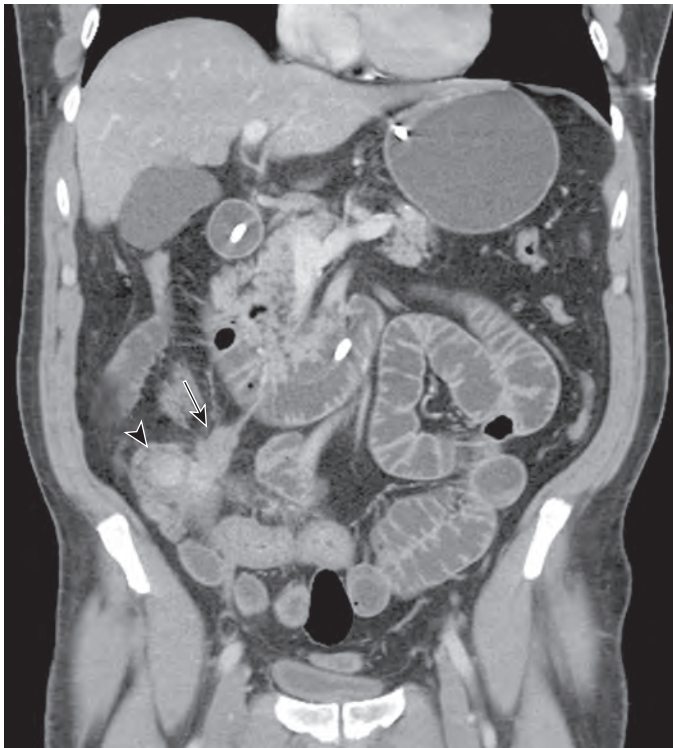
Mesenteric mass of small bowel carcinoid. Coronal CT reformation in a 68-year old man with carcinoid syndrome shows a hypervascular terminal ileal endoenteric mass (arrowhead), with an adjacent spiculated mass (arrow) in the mesentery. Spiculated mesenteric masses occur because of a desmoplastic reaction and need not contain tumor cells. Unlike this case, most mesenteric carcinoid lesions show calcification.
